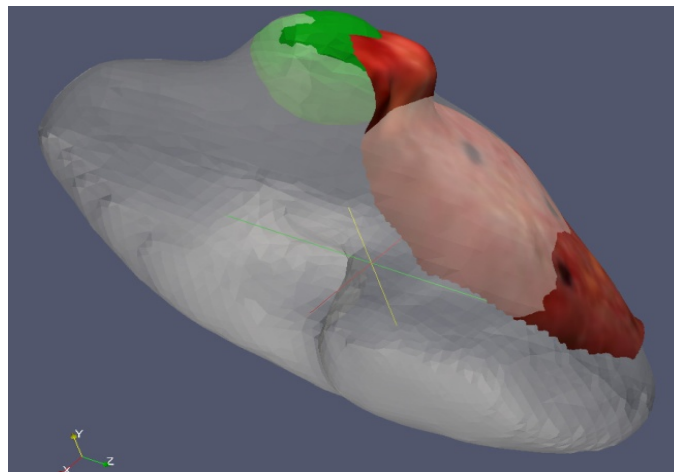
Initial LRS surface (red) registered to CT-derived kidney volume (gray) with tumor (green).
